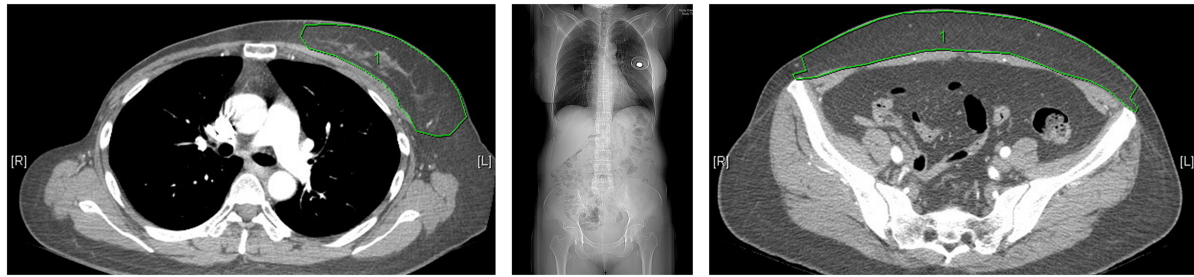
Measurement of breast volume (left) and DIEP flap volume (right) using computed tomographic angiography. The central image shows the scanned region, spanning from the clavicle to the abdomen, enabling comprehensive volume assessment. DIEP: Deep inferior epigastric artery perforator.
